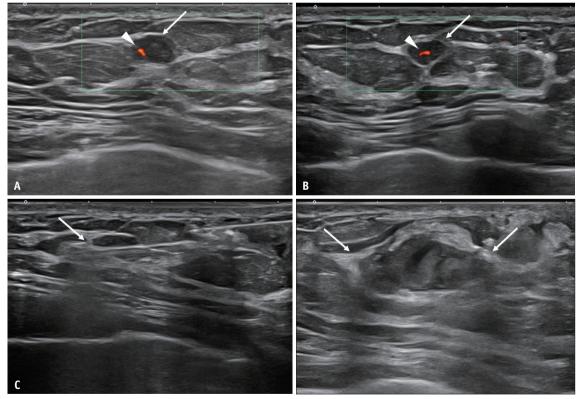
A 46-year-old woman presented with a right breast mass. A, B: Transverse (A) and longitudinal ultrasound (B) images show a solid mass (arrows) with a central vessel (arrowheads). C: Post-fire image shows the mass within the 14-gauge needle (arrow). D: Post-biopsy image shows a hematoma (arrows). Pathologic assessment revealed it to be a fibroadenoma.
